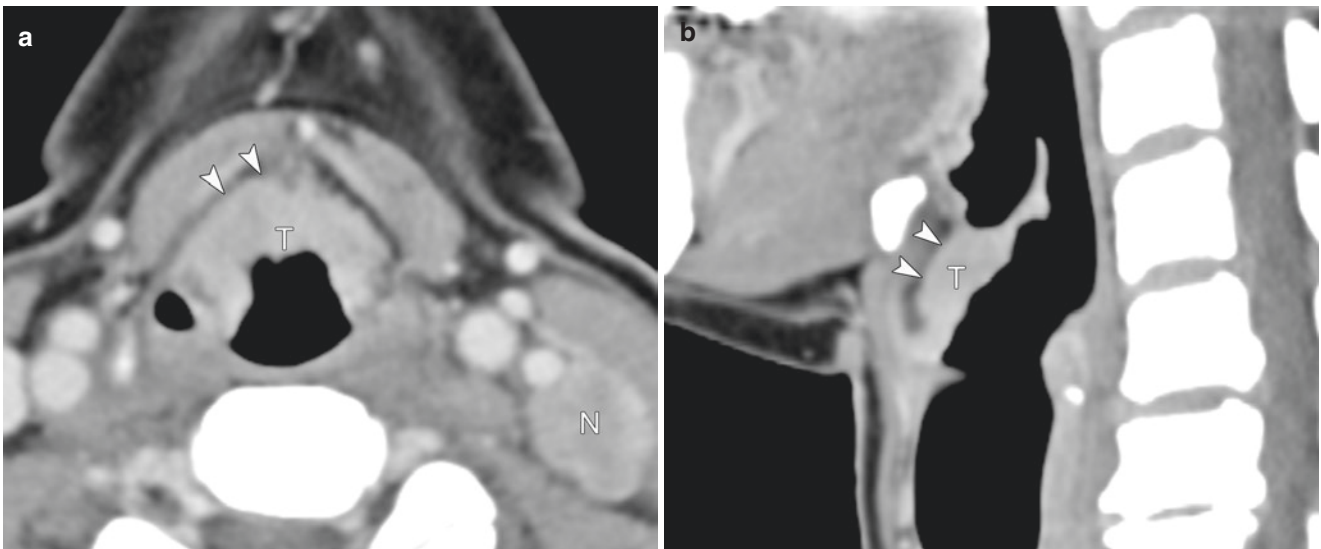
Supralaryngeal cancer of the infrahyoid epiglottis. Axial contrast-enhanced CT (a) and sagittal images (b) show a mass lesion (T) with an irregular margin on the infrahyoid epiglottis and extending
